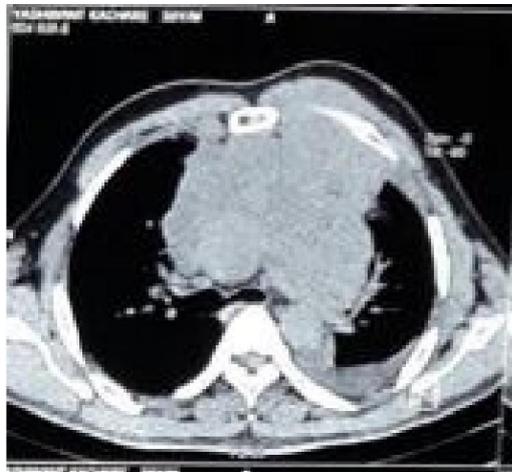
HRCT Chest shows anterior mediastinal mass with chest wall extension and left sided pleural effusion
